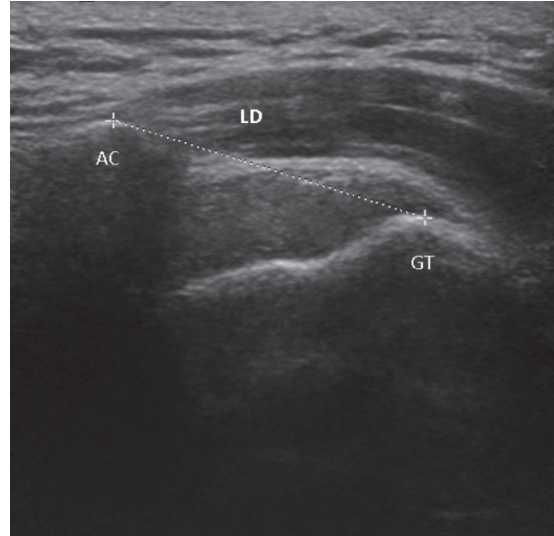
Ultrasound measurement of shoulder subluxation: the lateral distance (LD) was measured from the lateral border of the acromion to the greater tuberosity of the humerus. AC: acromion, GT: greater tuberosity.
